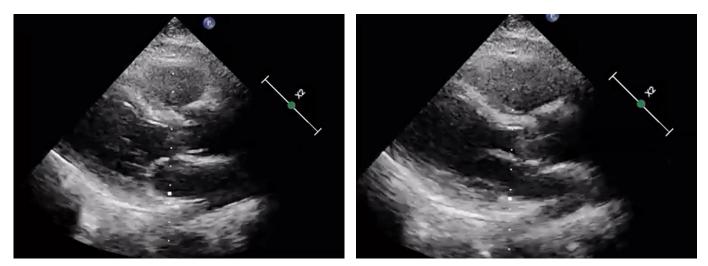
Transthoracic echocardiogram; parasternal long axis view showed an inferior wall hypokinesia with impaired left ventricular systolic function.
